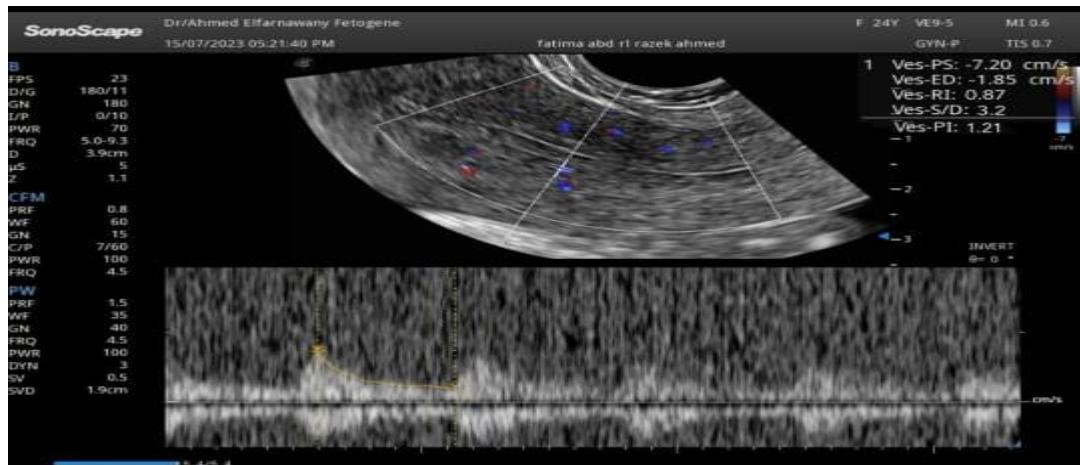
Subendometrial Doppler of a case who got pregnant after ICSI.
